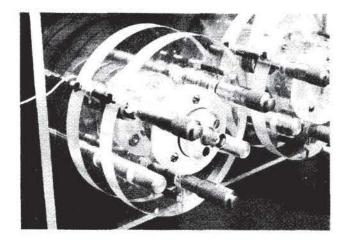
The ultrasonic tank.
